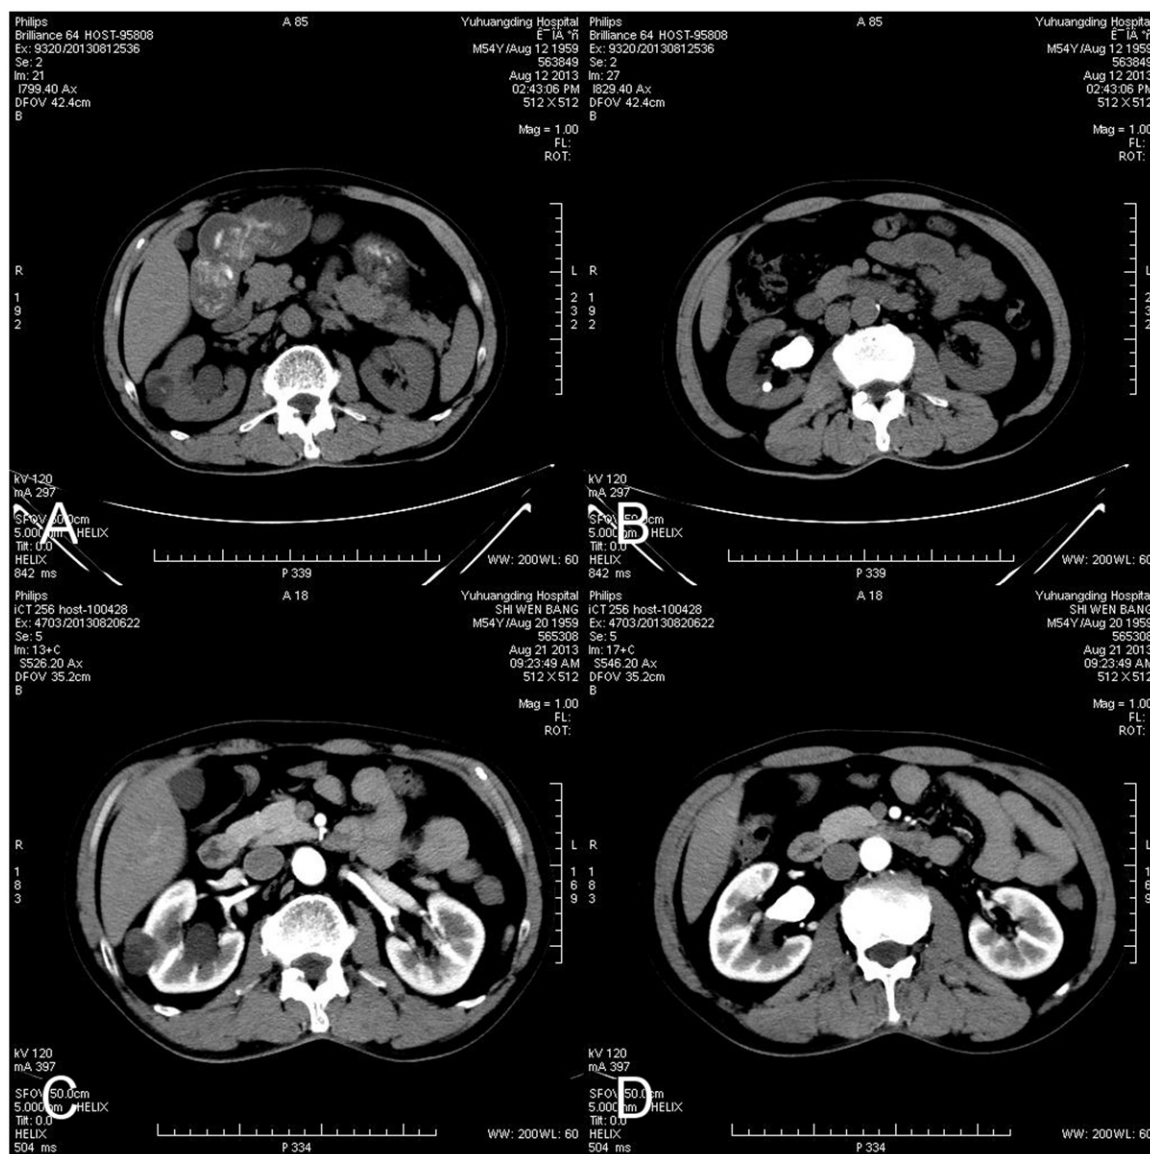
Non-contrast CT scan images of a patient with homolateral renal tumor (A) and renal calculus (B); and enhanced CT scan (C and D) of the same location. Tailed-arrows showed renal tumor and arrowheads indicated renal calculi.
